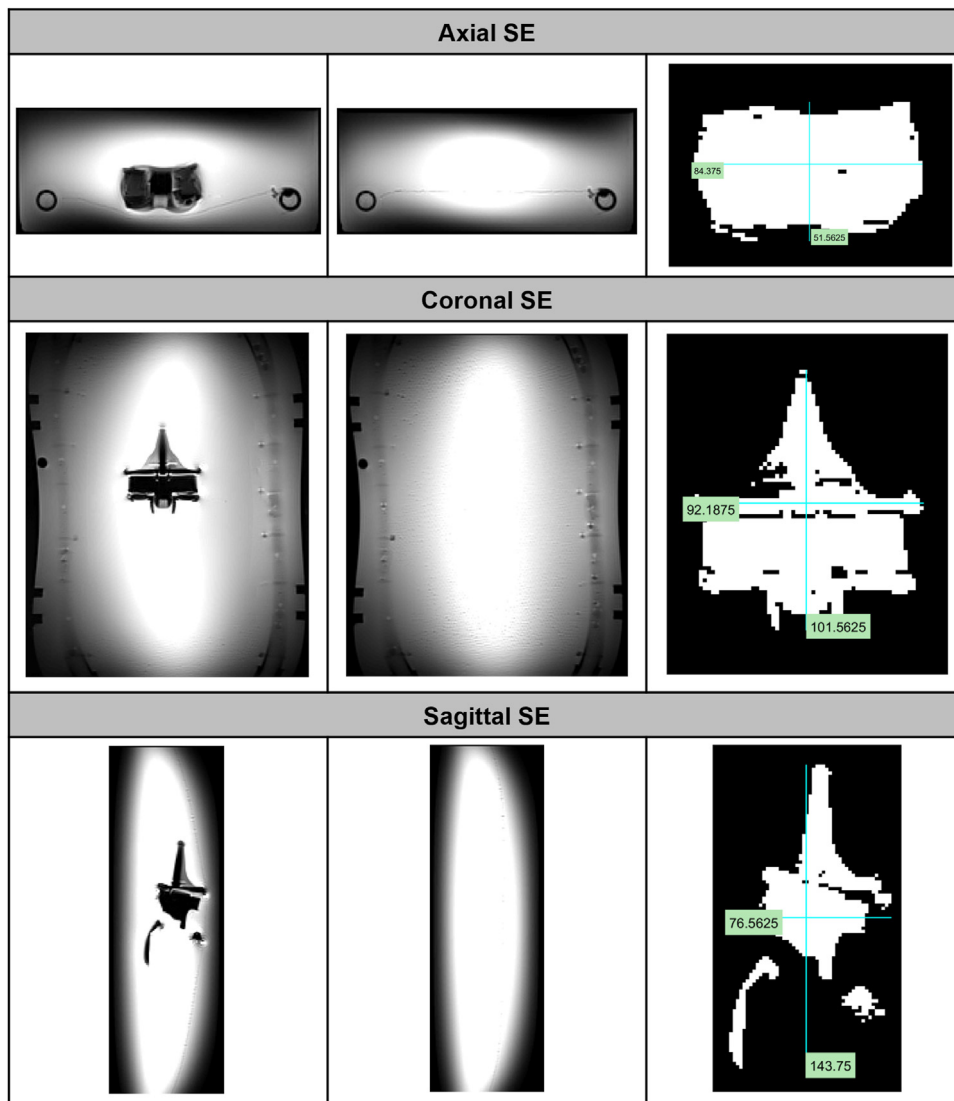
AMC ceramic knee with a spin echo pulse sequence in a 3T MRI system. Worst-case image (left), background image (middle), resulting image artifact (right). Measurements are in millimeters.
